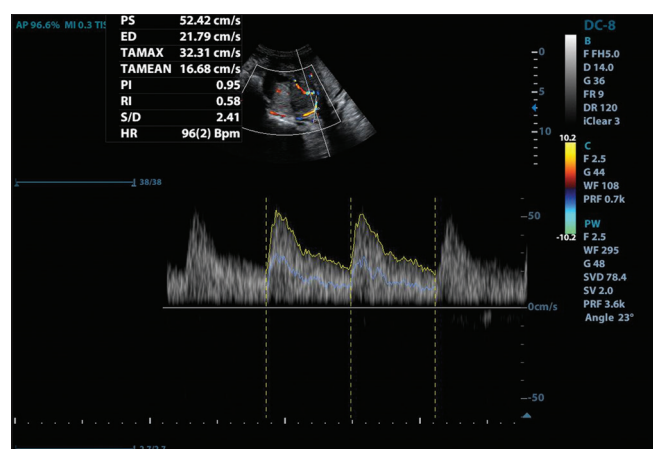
Pulsed Doppler examination of the uterine artery in a 56-year-old woman with International Federation of Gynecology and Obstetrics Stage IIIB cervical cancer, with high end-diastolic velocity = 21.79 cm/s, low resistive index = 0.58, and pulsatility index = 0.95
